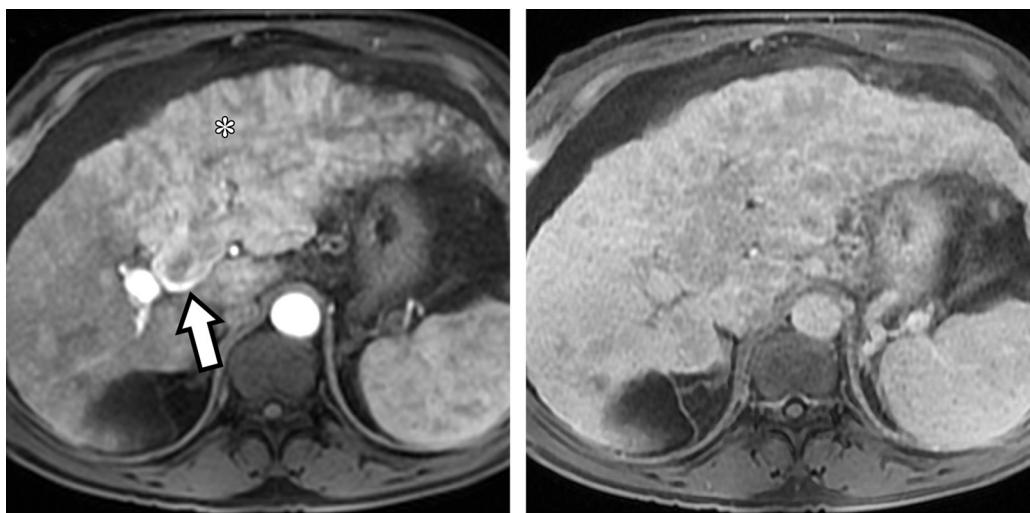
Infiltrative HCC in a 54-year-old man with a lesion categorized as LR-TIV (definitely TIV) on the basis of major imaging features. Axial dynamic late arterial phase (a) and delayed phase (b) MR images show an infiltrative HCC (* in a) with an enhancing TIV (arrow in a).
